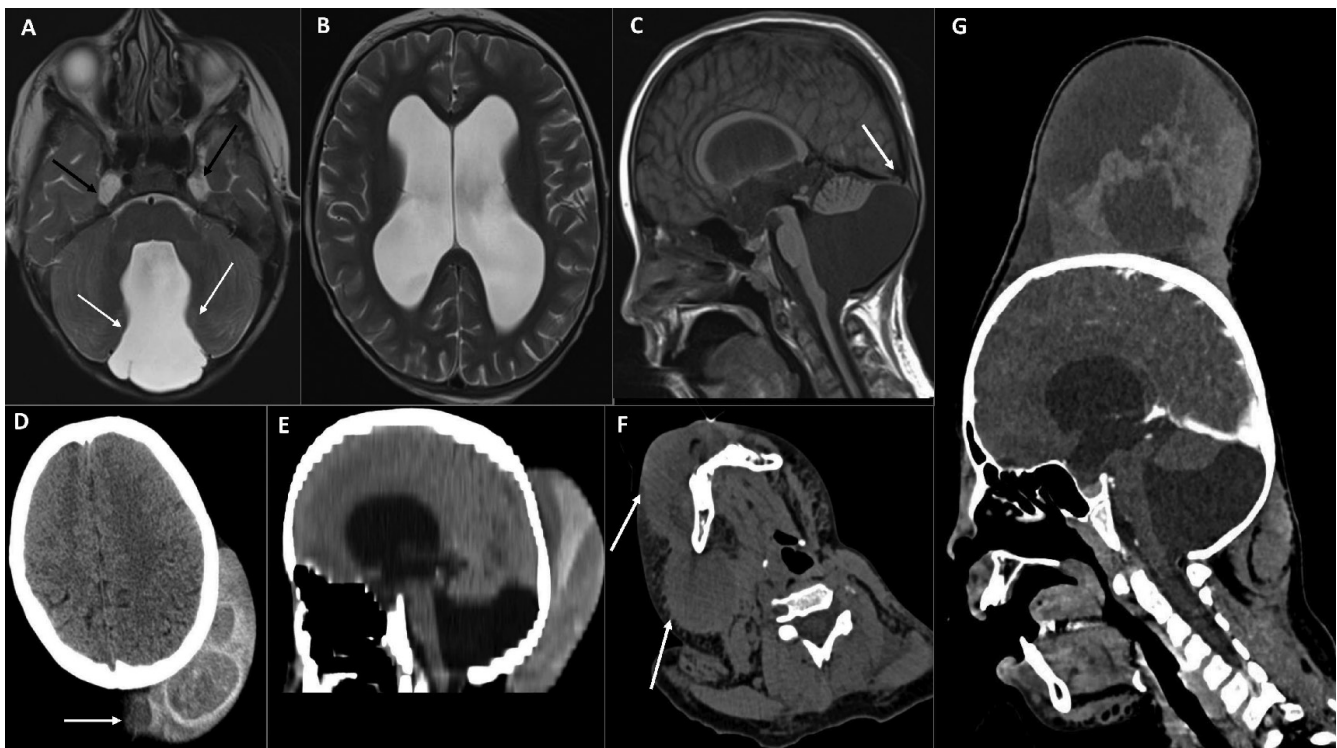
Cranial MR (A-C) obtained 7 years before trauma and CT imaging (D-G) obtained at the period of trauma. CT image reveals an acute subgaleal hematoma on the left parieto-occipital region with a 11.5 cm transvers in diameter without skull fracture (D)
